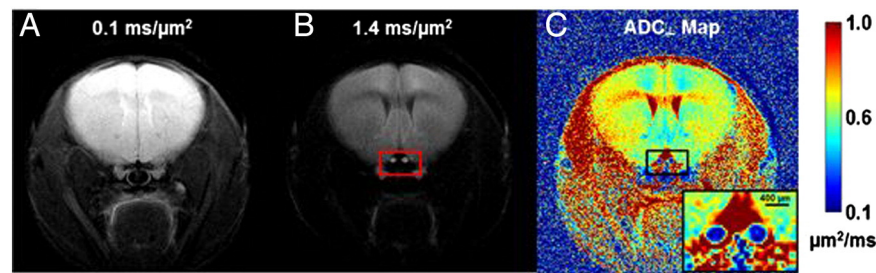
Two diffusion-weighted images (DWI), which were zero-filled to 512×512 , with diffusion-sensitizing gradients applied in the phase-encoding direction (left-to-right) with b values of $0.1 \text{ ms}/\mu\text{m}^2$ (or $100 \text{ s}/\text{mm}^2$) (A) and $1.4 \text{ ms}/\mu\text{m}^2$ (or $1400 \text{ s}/\text{mm}^2$) (B) were used to generate the resulting ADC_\perp map (C). The red box in panel B highlights the location of optic nerves (bright) and surrounding cerebrospinal fluid, which is highly suppressed. ADC_\perp values in the optic nerves are considerably lower than those in other brain tissues. The regular (nearly circular) shape of the optic nerves suggests good orthogonality between the nerve axes and the slice plane, which minimizes partial volume effects.
